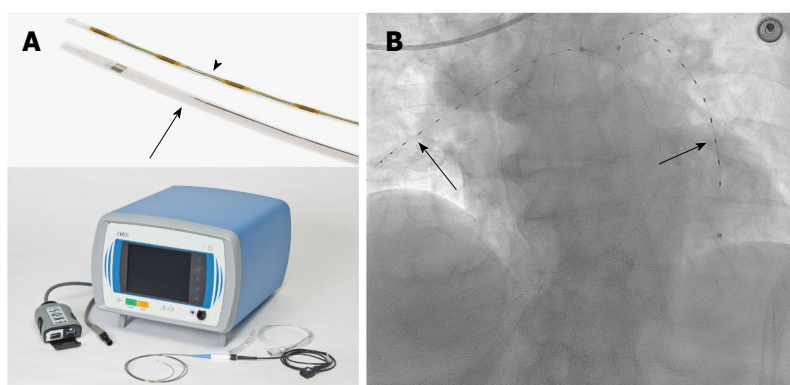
Ekos system. A: Ekos system with multiholed infusion catheter (arrow), ultrasonic core transducer (arrowhead) and control unit (Permission to use image granted by Ekos Corp., Bothell, WA, United States); B: Ekos catheters (arrows) with ultrasonic core transducers in place in the right and left pulmonary arteries.
